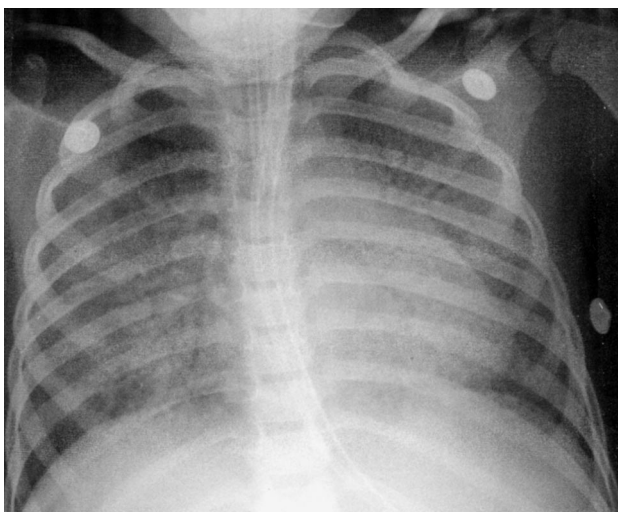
Anteroposterior chest radiograph taken 3 days after admission, following intubation, showing bilateral diffuse alveolar opacities.
